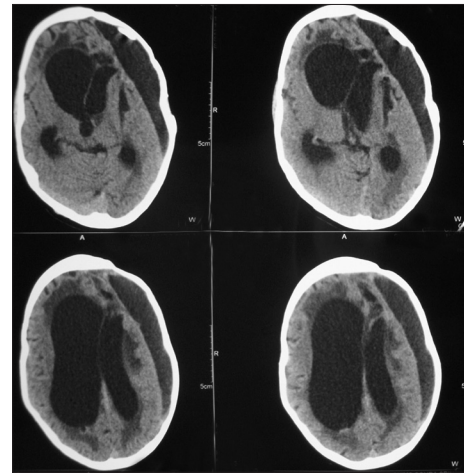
CT scan showing subdural hygroma with hydrocephalous
